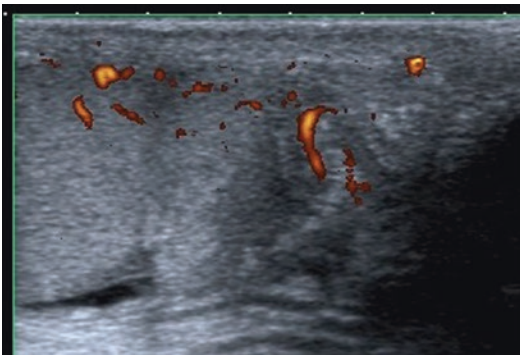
In testicular rupture, the power Doppler shows a portion of ischaemic parenchyma
